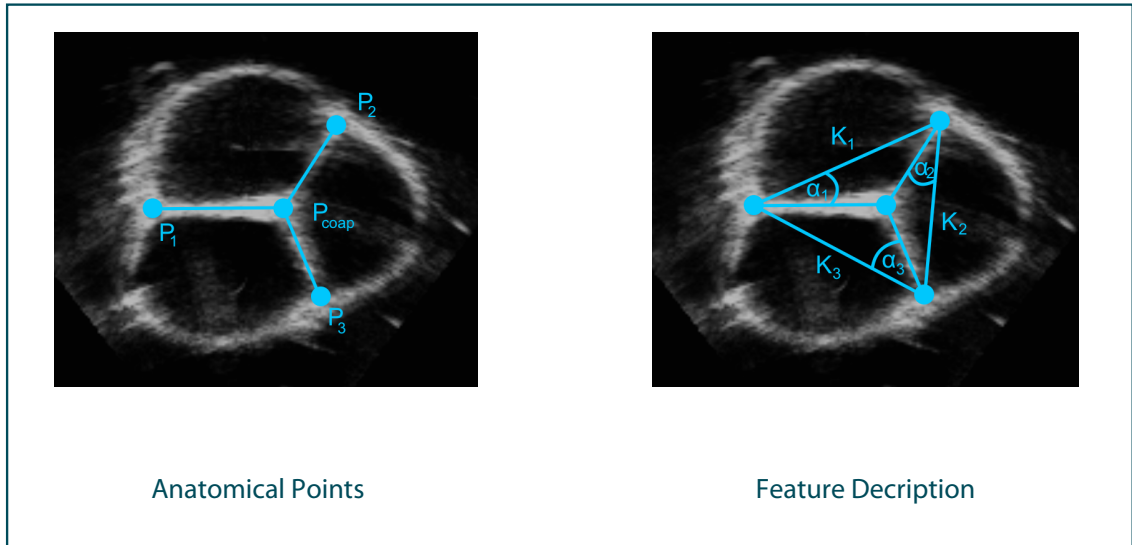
Anatomical points (left) and geometric features (right) extracted from ultrasound images. Note that the figure shows a two-dimensional projection of the three-dimensional geometry. Adapted from [61].
